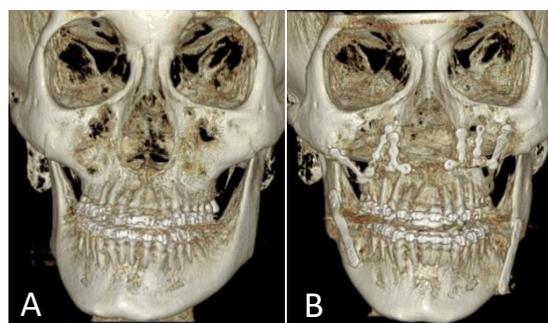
Changes of skeletal asymmetry seen on CBCT: (A) Before surgery, (B) Improvement of skeletal asymmetry after surgery
